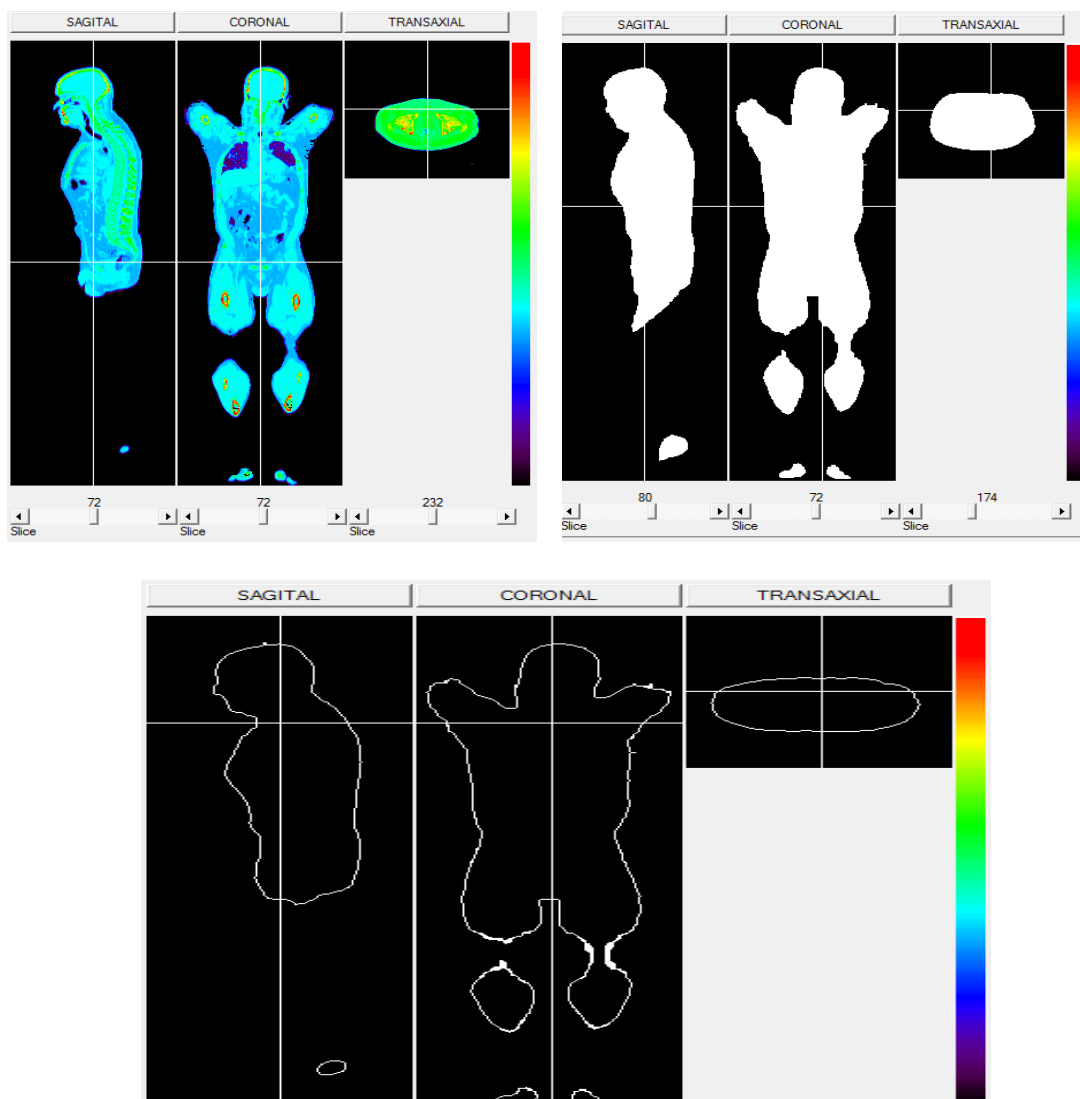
Examples of segmentation of the skin and body interior of the entire CT volume (1 slice shown for each of the sagittal, coronal and transaxial directions). Top left figure represent the original volume, the top right figure represents the mask of body interior and bottom figure represents the skin segmented.
